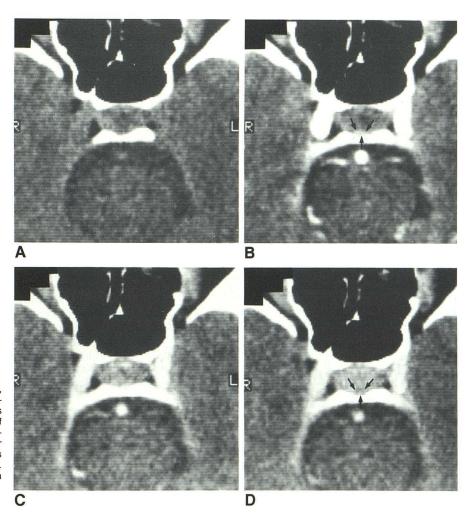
Axial dynamic CT scans of pituitary. A, Before bolus injection. B, 10 sec after bolus injection. Opacification of intracavernous carotid arteries and enhancement of intravascular compartment of posterior lobe (*arrows*). C, 20 sec after bolus injection. Enhancement of anterior pituitary. Posterior lobe is not seen clearly. D, 50 sec after bolus injection. Maximal enhancement of anterior lobe. Posterior lobe appears as low-density area (*arrows*).
